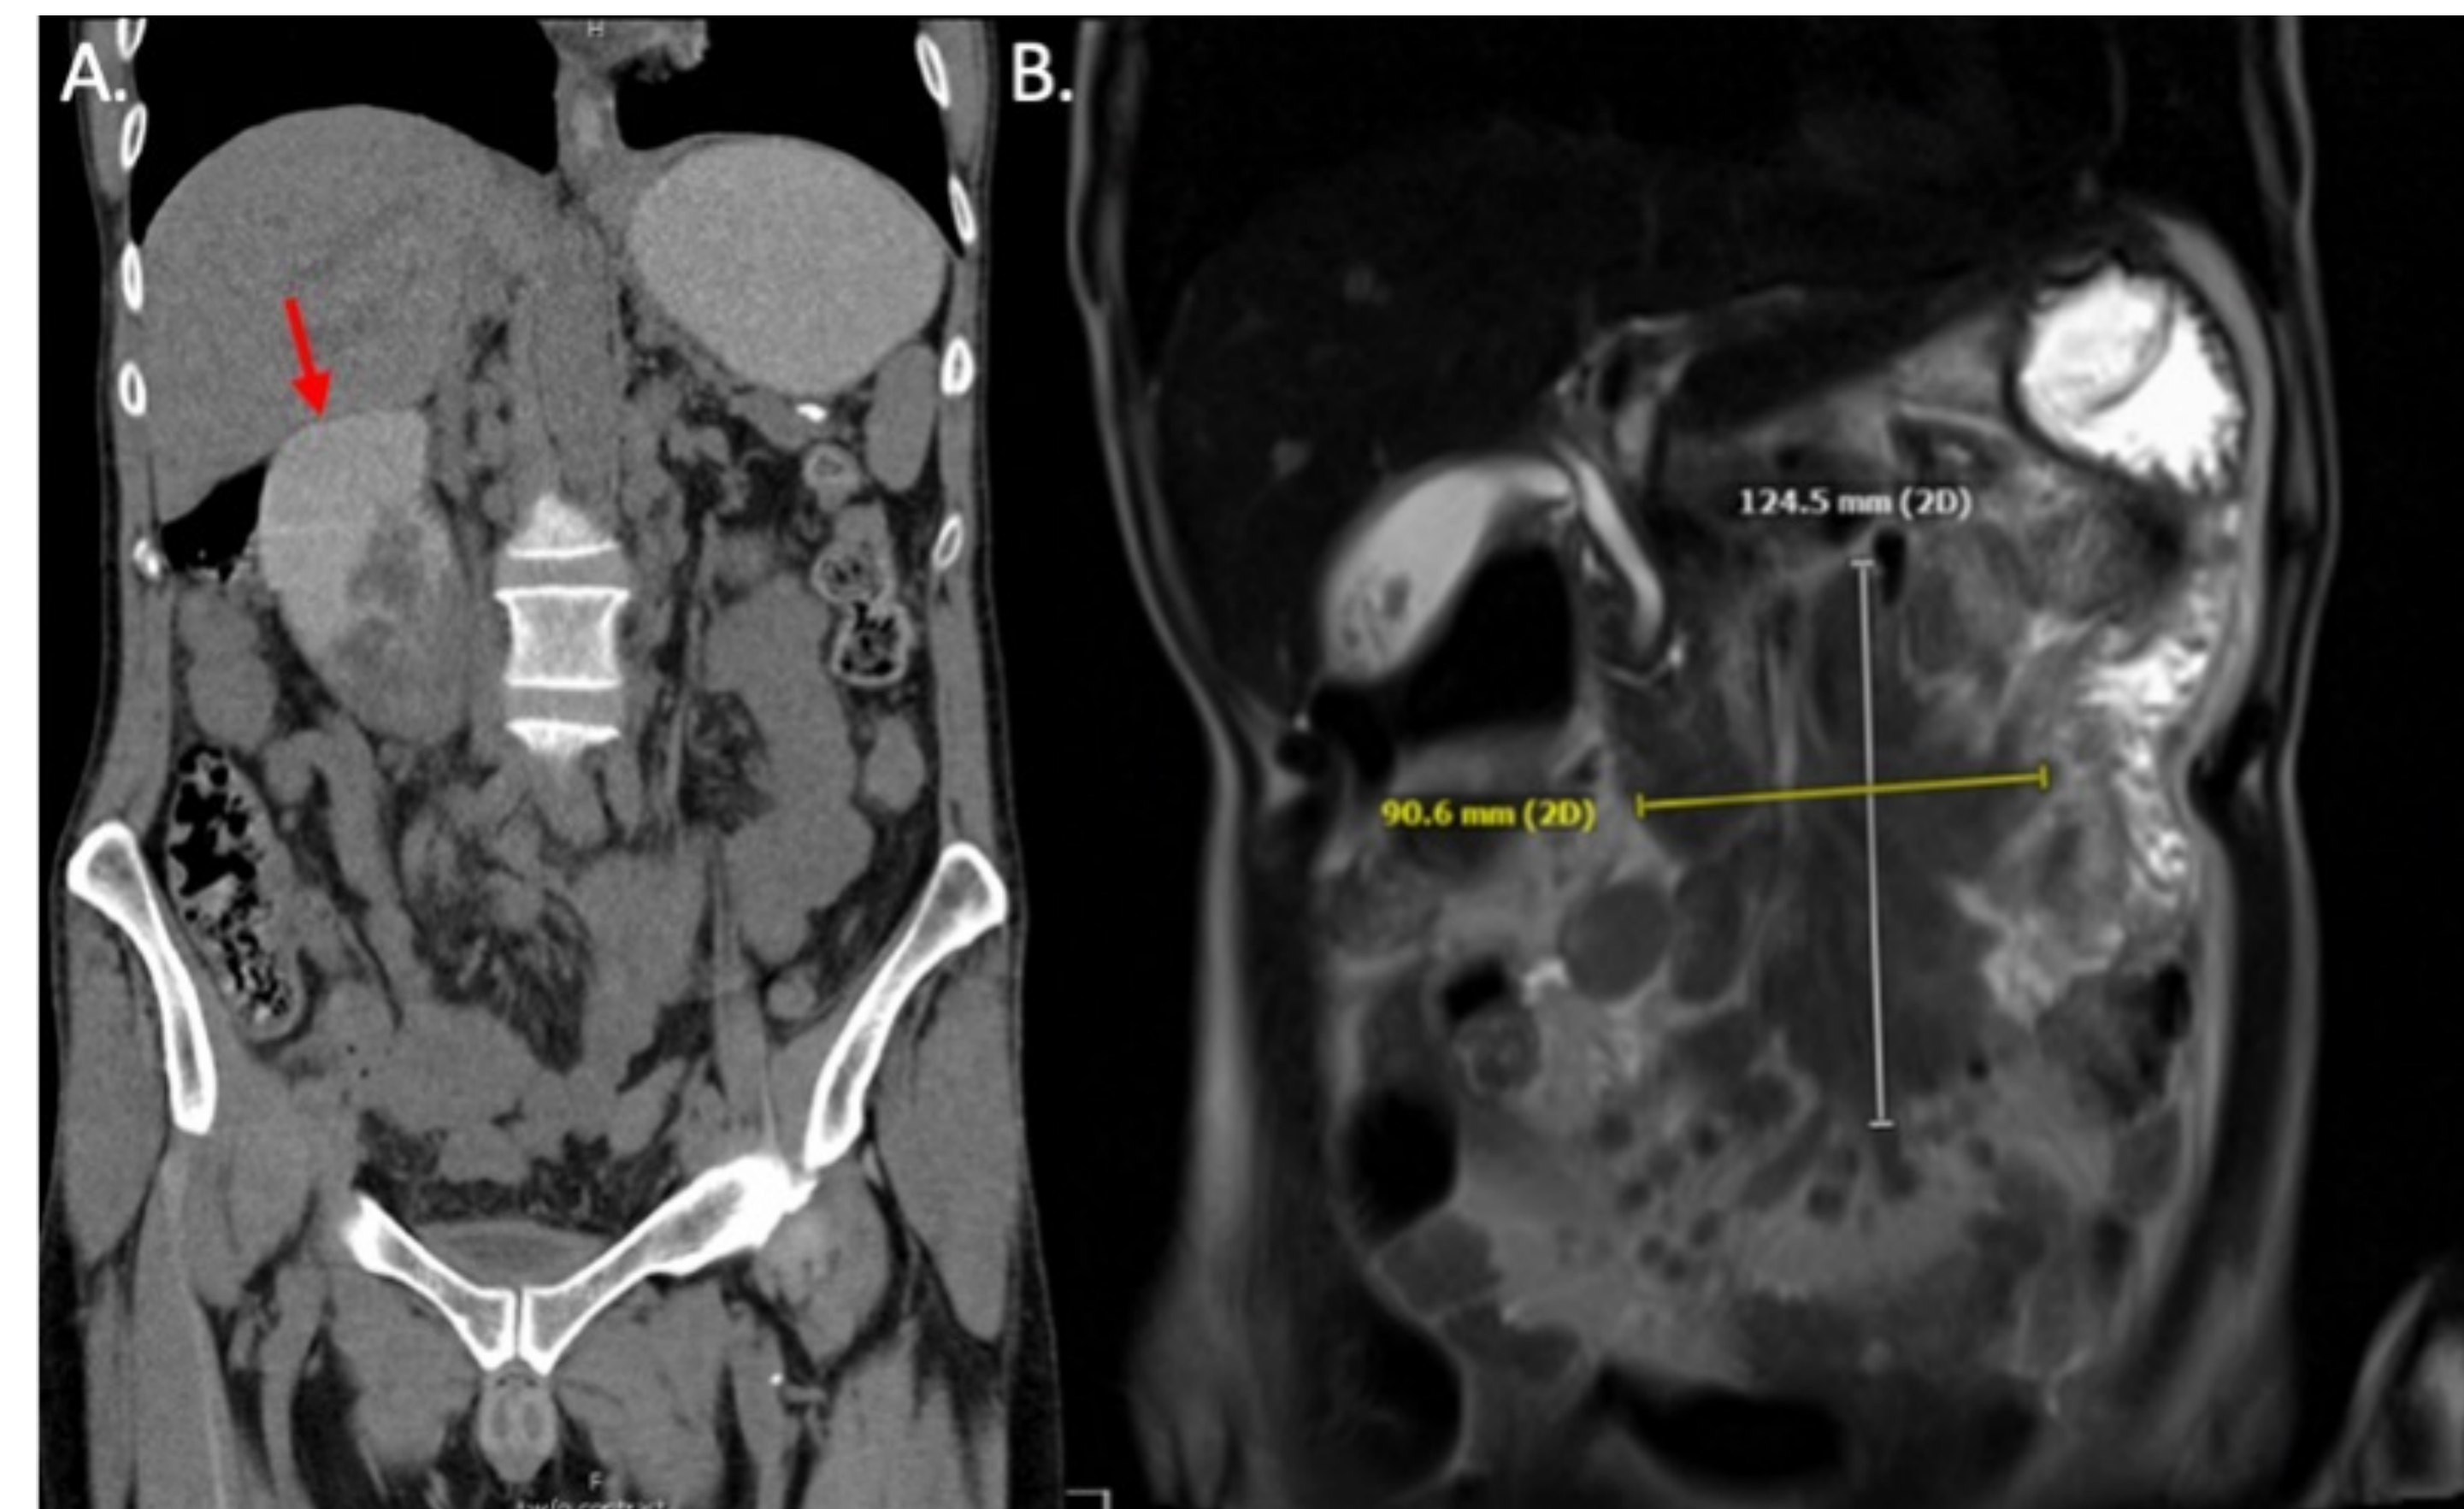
(A) Computed tomography and (B) Magnetic resonance imaging revealed a conglomerate mesenteric nodal mass concerning for lymphoma. The mass was found to be compressing the horizontal segment of the duodenum resulting in a duodenal outlet obstruction
